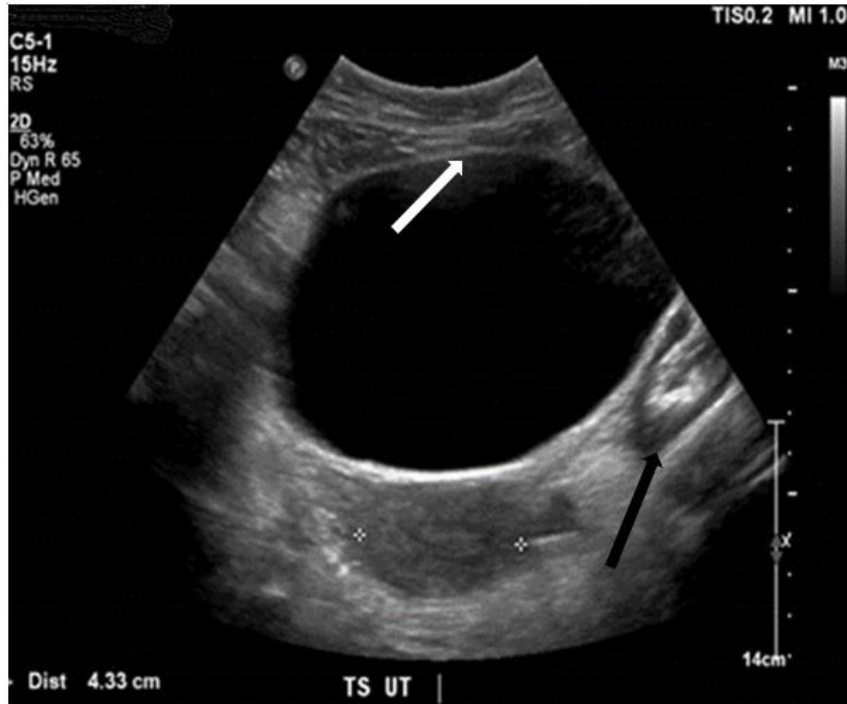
Point-of-care ultrasound scan of bladder as an anechoic mass (white arrow) in relation to the pubic bone (black arrow) and uterus (+).
